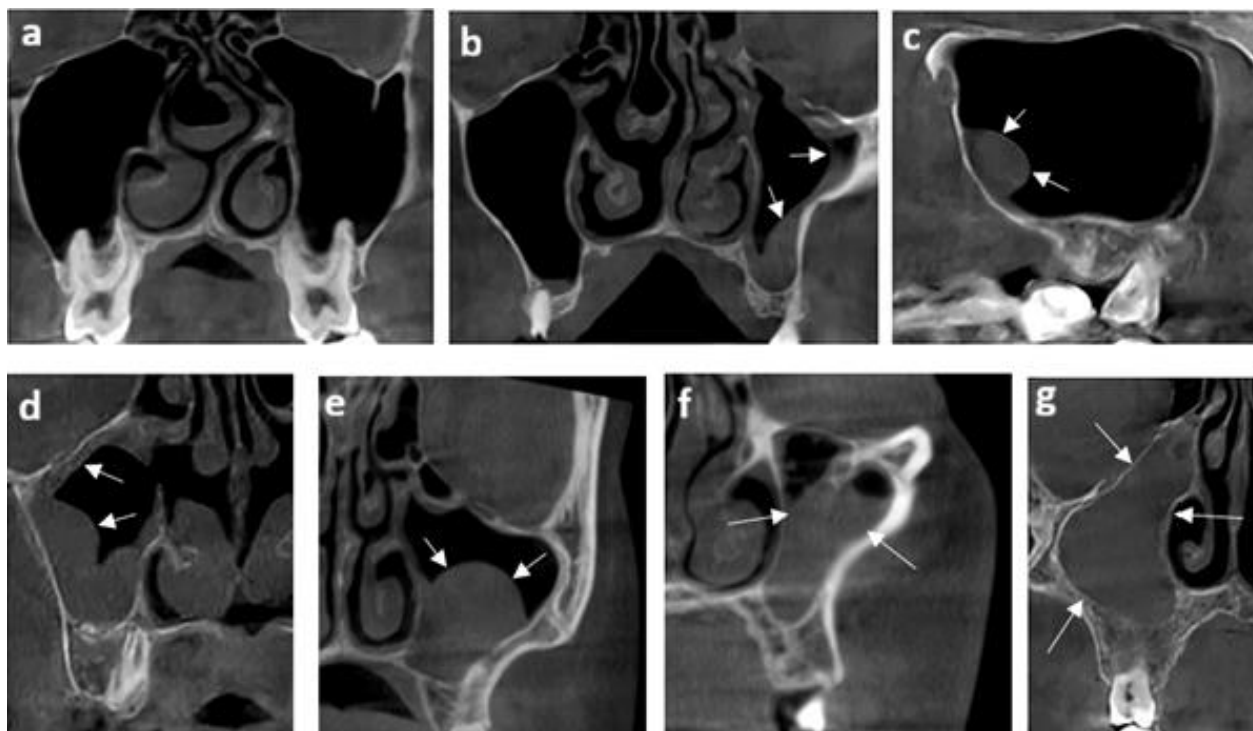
Cone-beam computed tomography (CBCT) images of maxillary sinus pathologies, a: no pathological findings (coronal view), b: mucosal thickening (coronal view), c: polypoid structure (sagittal view), d: mucosal thickening and polypoid structures (coronal view), e: retention cyst (coronal view), f: partial opacity (coronal view), g: total opacity (coronal view)
